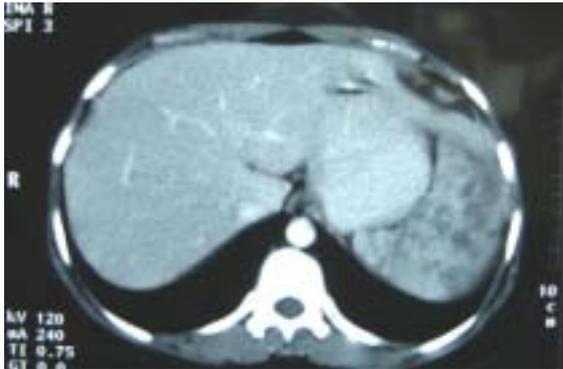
Contrast enhanced spiral CT examination of abdomen showing splenomegaly with multiple hypodense cystic lesions with ill defined margins likely to be splenic abscesses.
